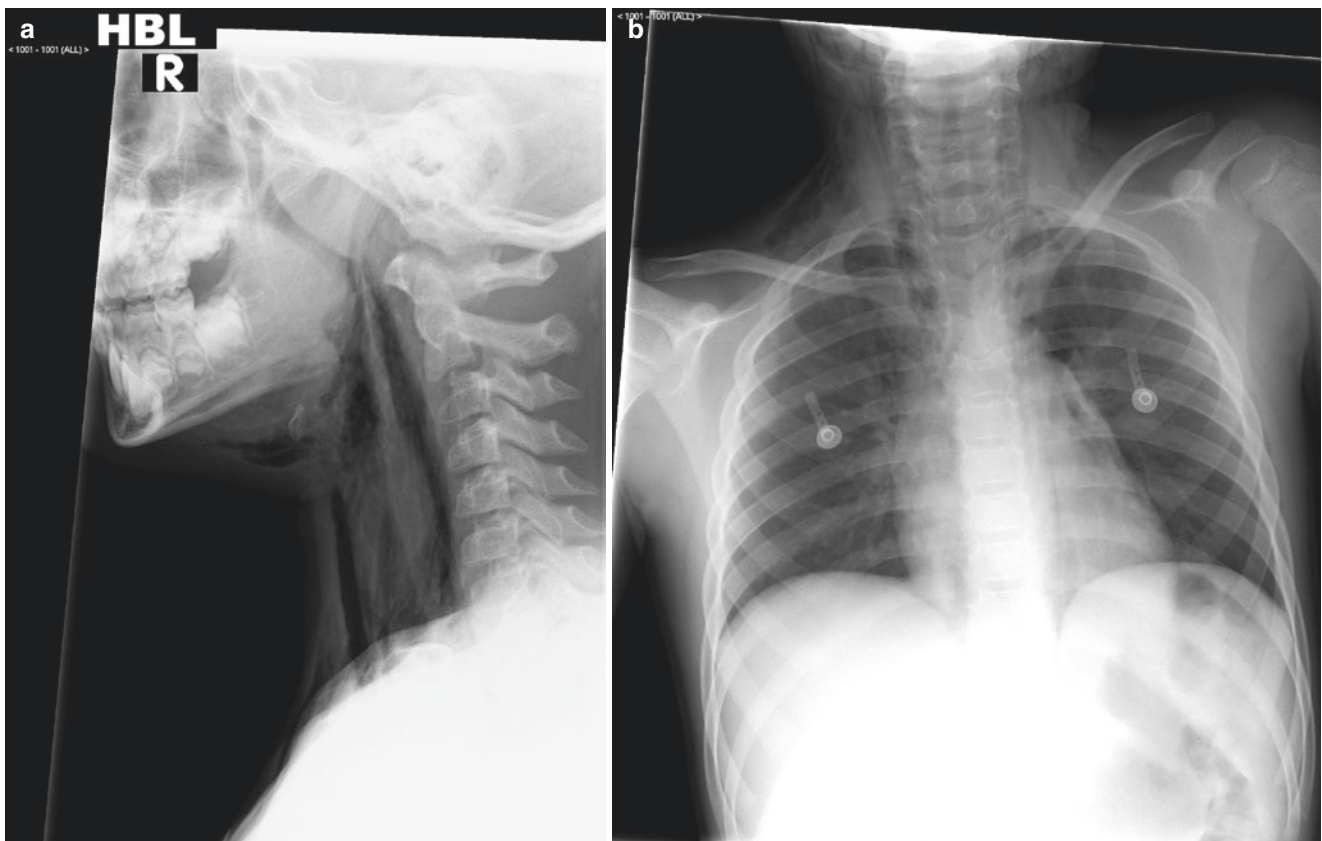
(a) Surgical emphysema in the neck. Lateral view plain X-ray. (b) Surgical emphysema
